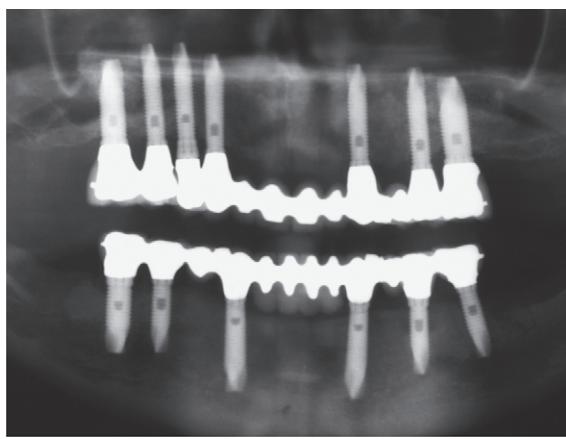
Radiograph of the patient in Fig. 13.53, showing fixed restorations supported by seven implants in the maxilla and six in the mandible.
